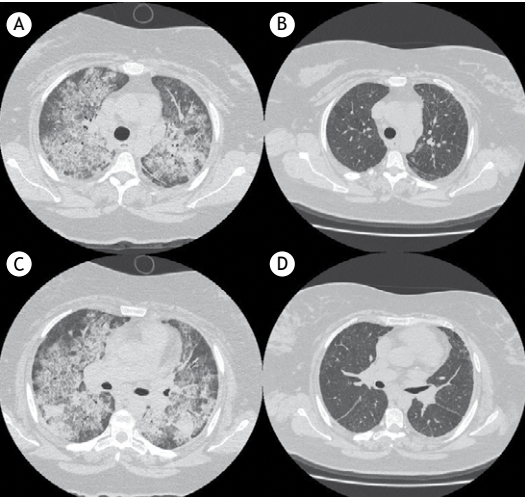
CT scans of the chest of a patient with pulmonary alveolar proteinosis, showing diffuse ground-glass opacities and interlobular septal thickening (the crazy-paving pattern). In A and C, chest CT scans performed before whole-lung lavage. In B and D, chest CT scans performed after the procedure, showing improvement.
